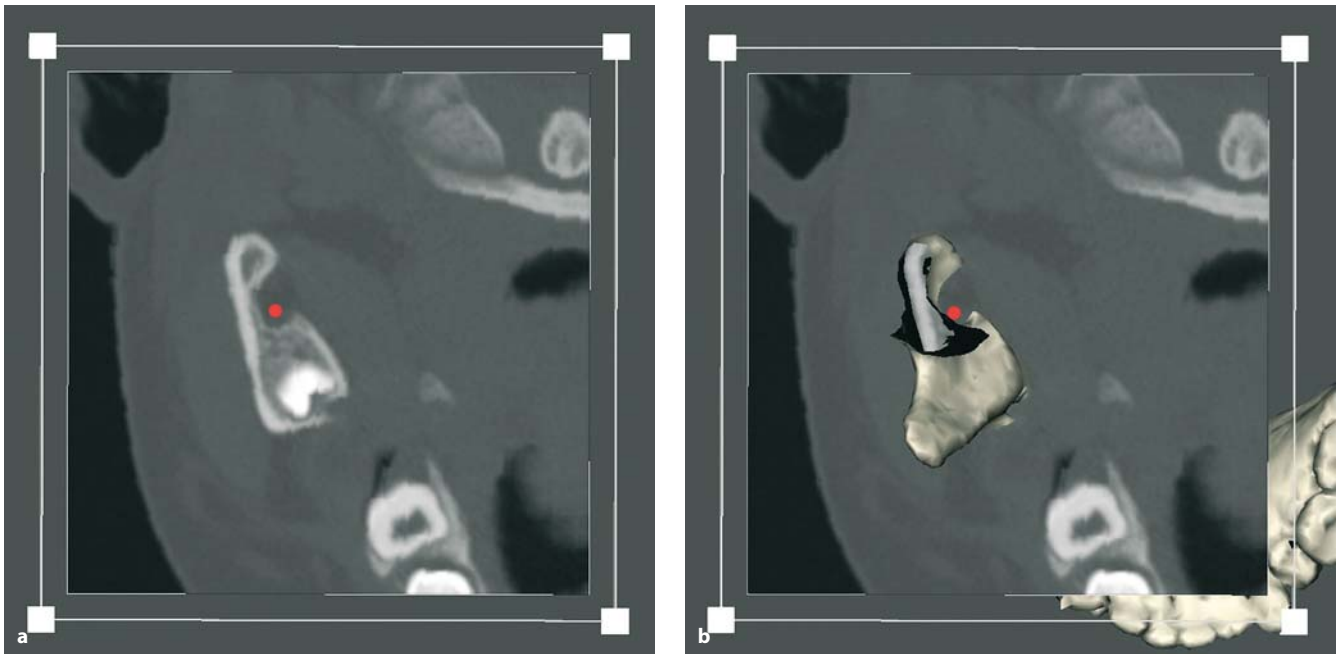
a, b. Orbitomeatally oriented axial CT at the level of the lingula shows the entrance of the inferior alveolar nerve in the right vertical mandibular ramus. a Axial CT; b axial CT with overlay of 3-D hard tissue surface representation of the mandible (patient B.R.)
